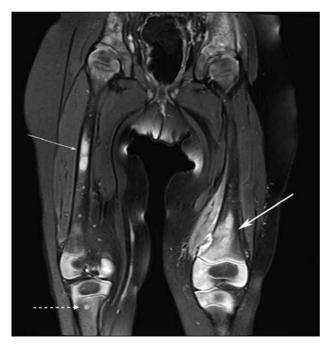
Fat-suppressed coronal T2-weighted magnetic resonance imaging of the thighs showing extensive signal abnormality in the distal left femoral metaphysis (thick arrow). There are asymptomatic lesions in the right femoral diaphysis (thin arrow) and right proximal tibial metaphysis (dashed arrow), and diffusely abnormal marrow signal in the pelvis.
